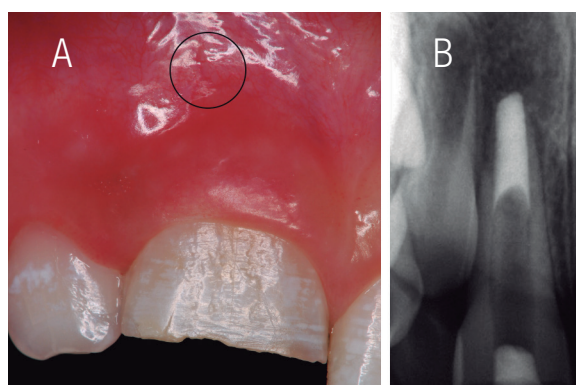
Endodontic treatment was performed and an apical plug was made with mineral trioxide aggregate. Note how the gingiva was repaired after the endodontic treatment (A). The patient was referred for placement of an intra-radicular post in order to strengthen the intra-radicular tooth structure. Note the endodontic treatment in the periapical radiograph of the central incisor, and the amplitude in the region of the root canal with fragility of the intra-radicular walls (B).
